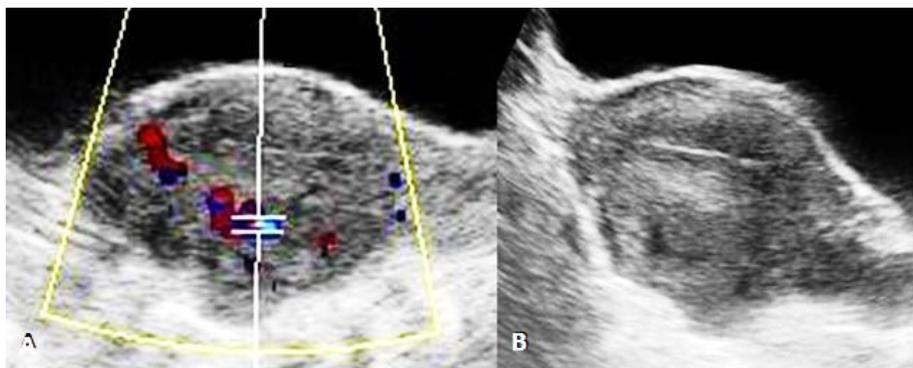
(A)(B) Color doppler and greyscale ultrasound images of the pelvis in a patient presenting with menorrhagia showing ill-defined heterogeneous hypoechoic lesion showing peripheral vascularity on doppler study seen indenting the endometrium anteriorly Intramural Fibroid.
